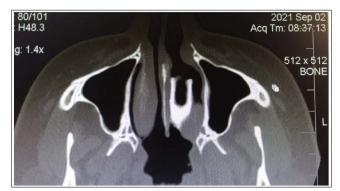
CT Scan Depicting Left-Side Foreign Body (Axial View)
